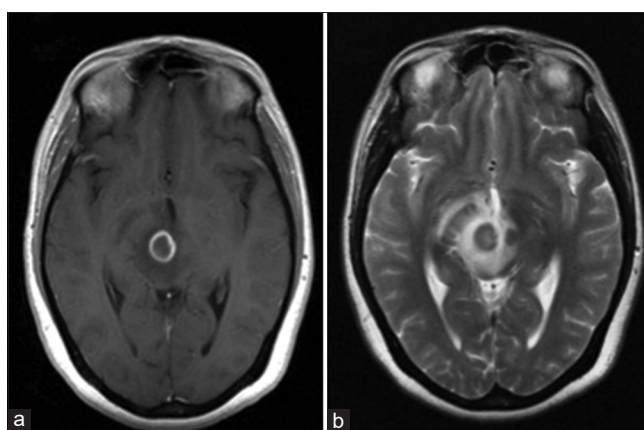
Peripheral (rim) portion of midbrain lesion characteristic of an abscess with smooth rim enhancement on gadolinium enhancement T1-weighted image (a) and low signal intensity rim with associated profound edema on T2-weighted image (b)
